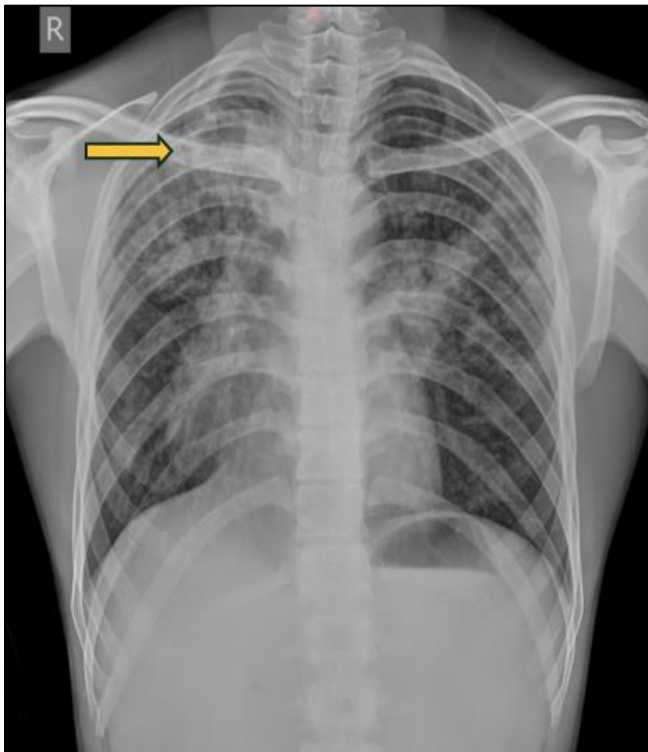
(A and B): Chest x-ray PA projection Showing Fibrotic Changes in Bilateral Upper Lobes and Cavitary Lesion in Right Upper Lobe.
